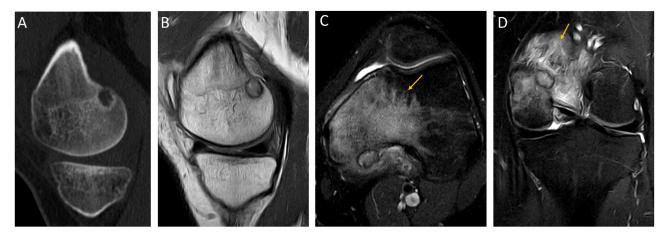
A. 20-year-old-male with pain and swelling of the knee. CT (A) of the left knee shows a well-defined lytic lesion with a thin sclerotic margin in the posterior area of the medial femoral condyle. On T1WI (B) and axial and coronal FS T2WI (C and D) the lesion shows typical chondroid signal as well as intense bone marrow and soft tissue edema (arrows). The pathological anatomy (not shown) confirmed the diagnosis of chondroblastoma. (Color version of figure is available online.)
